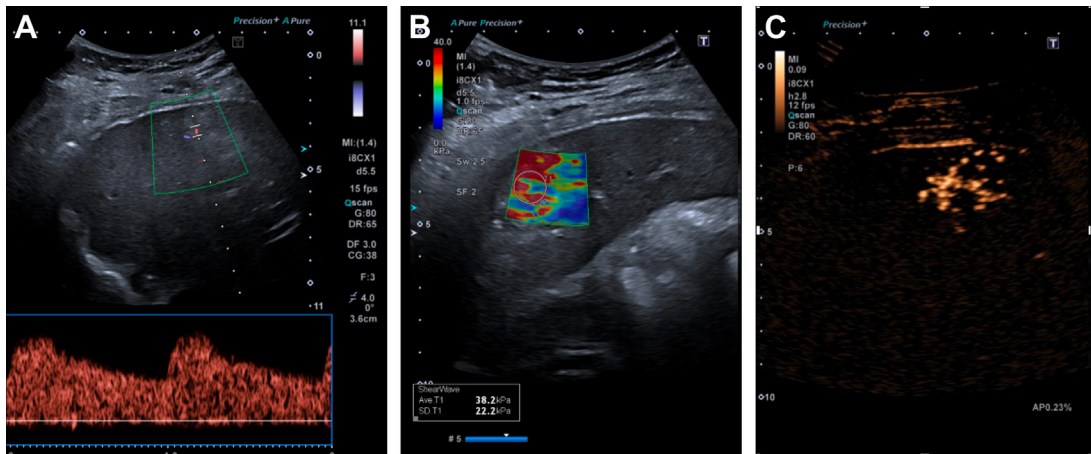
Typical sonographic features of focal nodular hyperplasia. Color Doppler examination reveals the presence of a penetrating arterial vessel (A), and shear wave elastography shows high stiffness values (B). On contrast-enhanced ultrasound, after the injection of 2.4 mL of sulfur hexafluoride SonoVue, the lesion was enhanced in the arterial phase, demonstrating a typical spoke-wheel aspect with centrifugal distribution (C).
